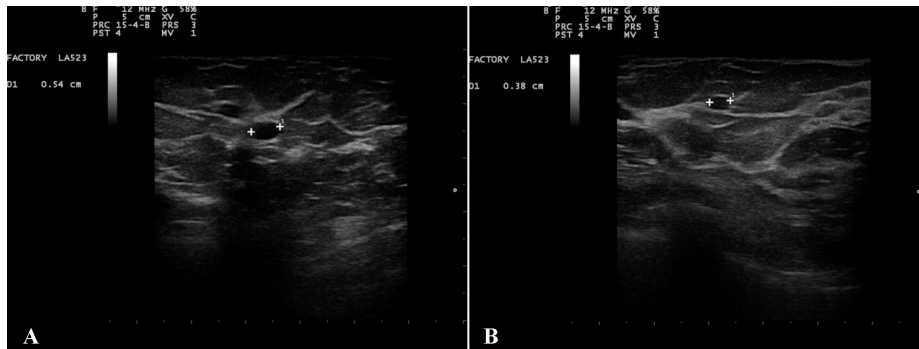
Ultrasonography of breast cyst. A 62-year-old woman was diagnosed with multiple myeloma. After 4 weeks of integrative immunotherapy where OA-GcMAF (880 ng/day) was administered by intramuscular injections, the diameter of one benign breast cysts decreased from 5.4 mm (panel A) to 3.8 mm (panel B). This corresponds to approximately a 65% overall reduction
